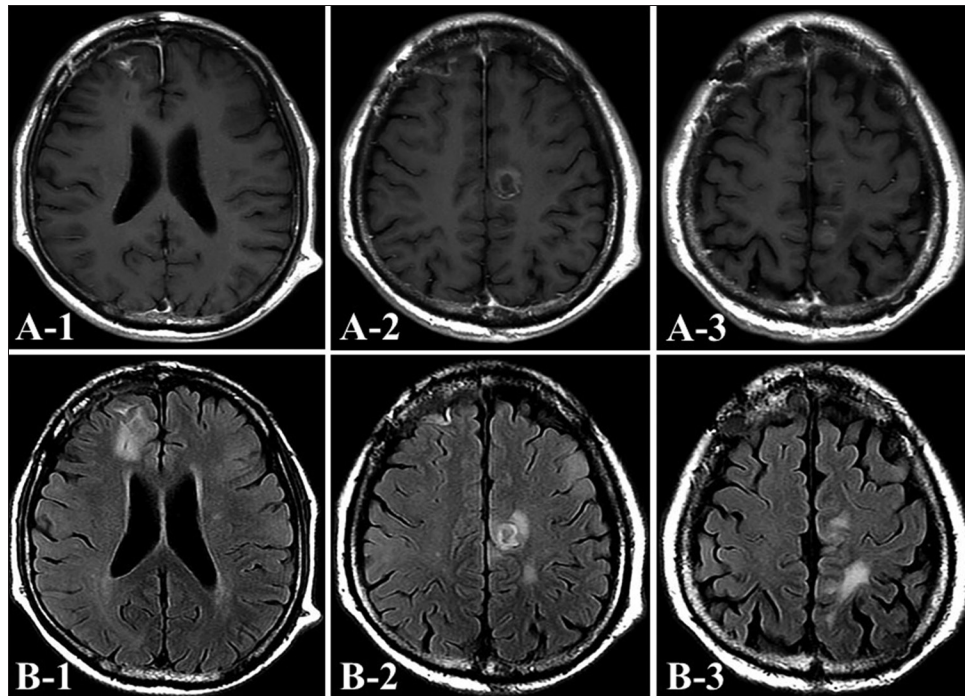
Axial gadolinium-enhanced T1-weighted imaging (a) and fluid-attenuated inversion recovery (b) magnetic resonance imaging at 10 months after administration of bevacizumab has clearly decreased in size and peritumoral edema.
